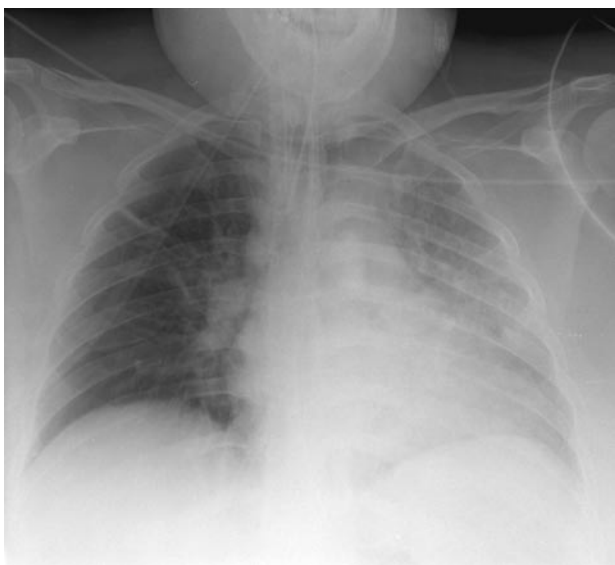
Immediate postoperative chest radiograph showing pulmonary edema restricted to the left lung.
